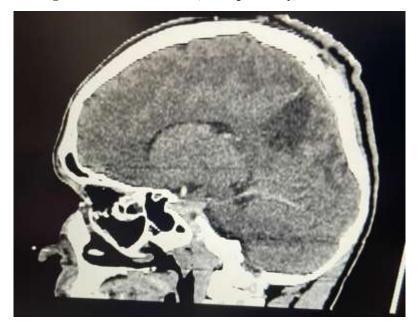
Cerebral CT Scan, Postoperatively, Sagittal View
